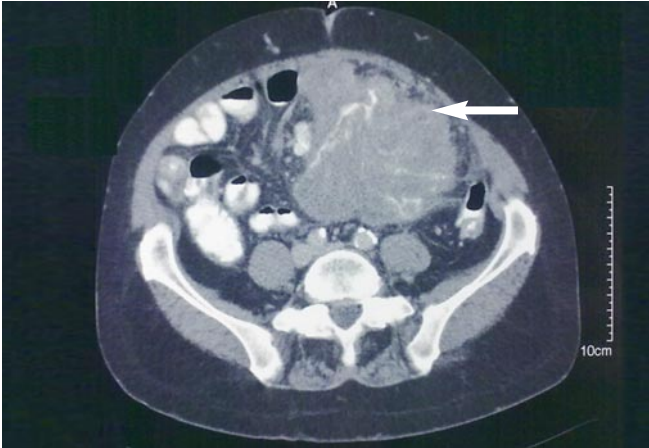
Computed tomography (CT) scan showing a left abdominal mass (arrow).
